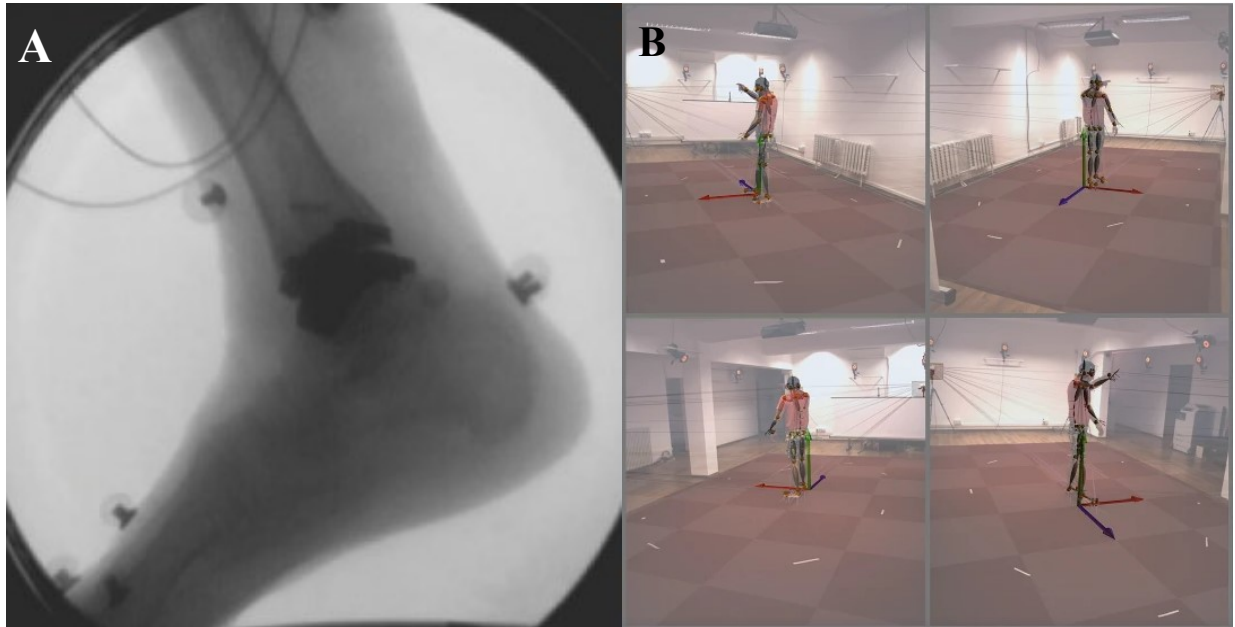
Two common strategies for measuring skeletal kinematics. A, image from X-ray fluoroscope; B, optical motion capture. Panel A is reproduced from Blair et al. [2] and is licensed under Creative Commons Attribution License (CC BY). Panel B is reproduced from Malleson et al. [3] and is licensed under Creative Commons Attribution 4.0 International.
